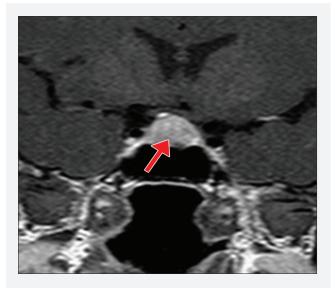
Magnetic resonance imaging (MRI) showing a 15 mm pituitary macroadenoma.
